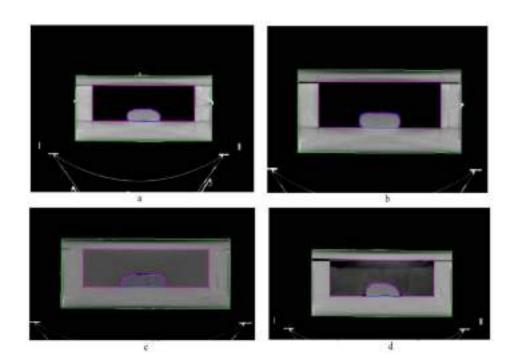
Axial CT view for different medium used for blood irradiation study: (a) air; (b) thermocole; (c) water; (d) rice powder.
